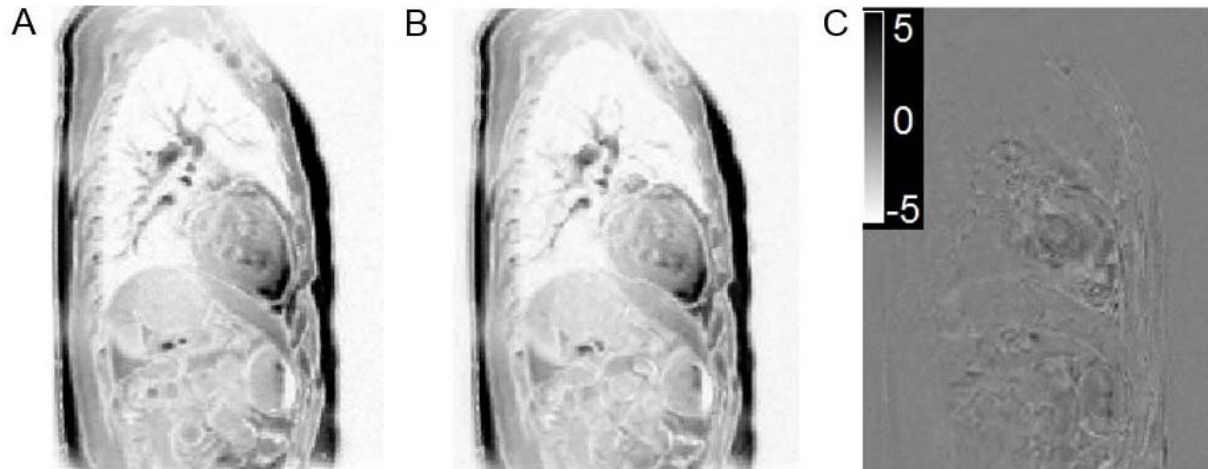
(A) The sagittal view of a slice of an acquired MR image. (B) Same slice of the corresponding generated MR image. (C) Difference image between the two images.
